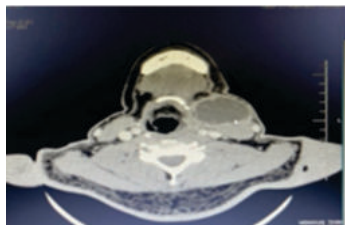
CT Neck showing a well-defined hypodense peripherally enhancing lesion in the left side of the neck, anterior to carotid, jugular vessels and sternocleidomastoid muscle.
